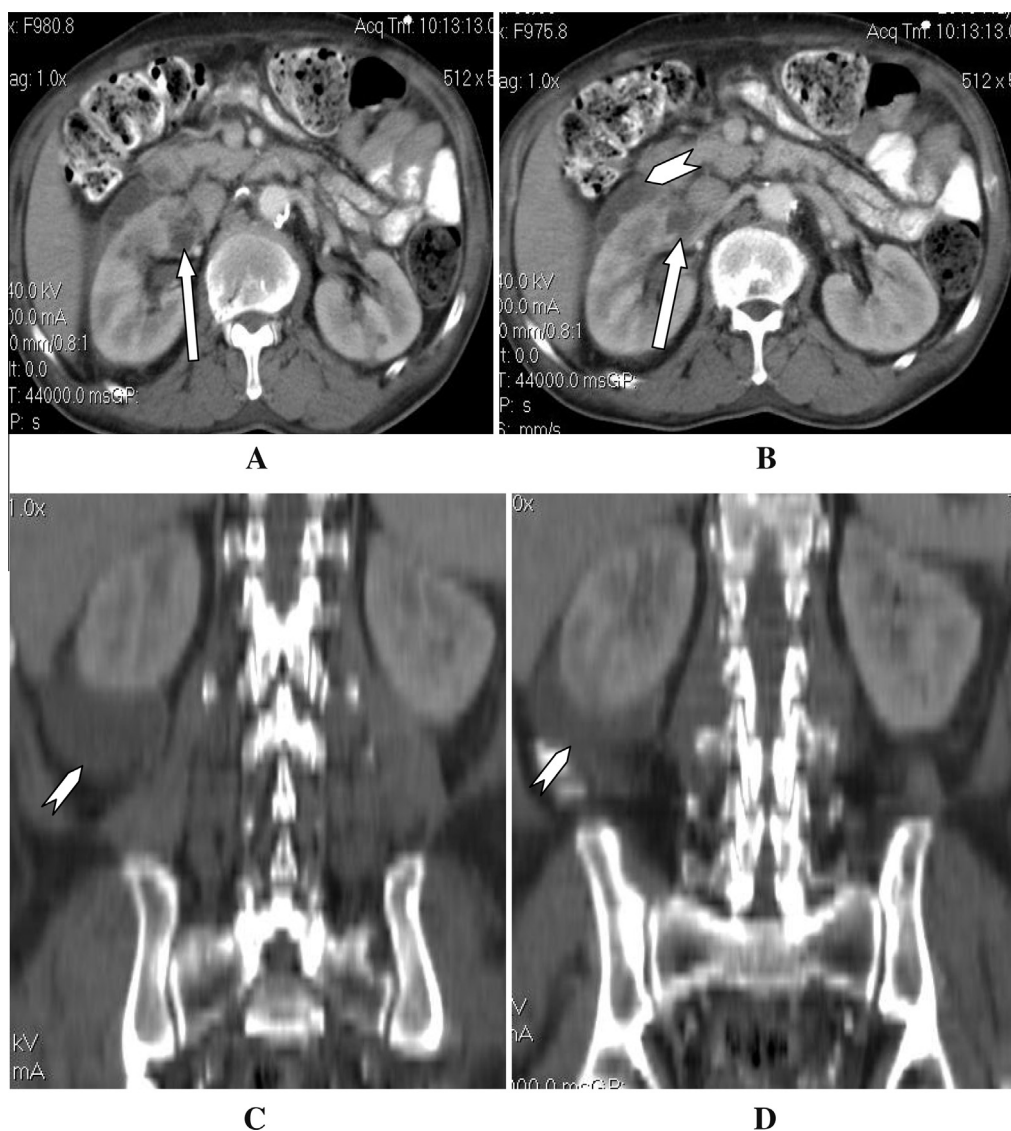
Post contrast CT scan Axial (A and B) and coronal reformat (C and D) showing right renal upper polar carbuncle (Arrow) with massive perinephric collection (chevron).
